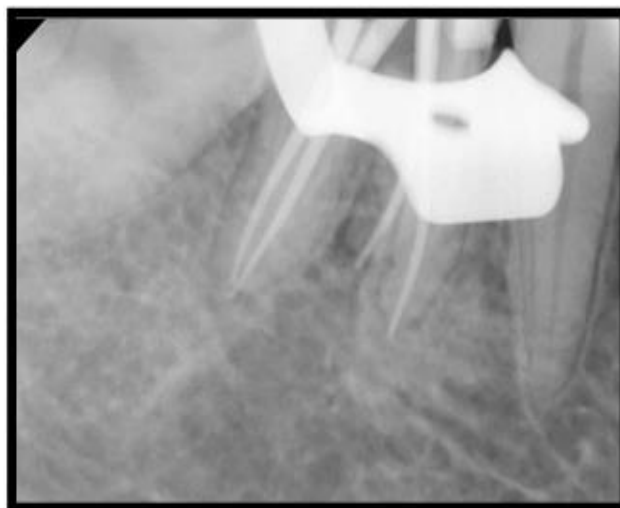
Radiograph showing master cone verification of #46
